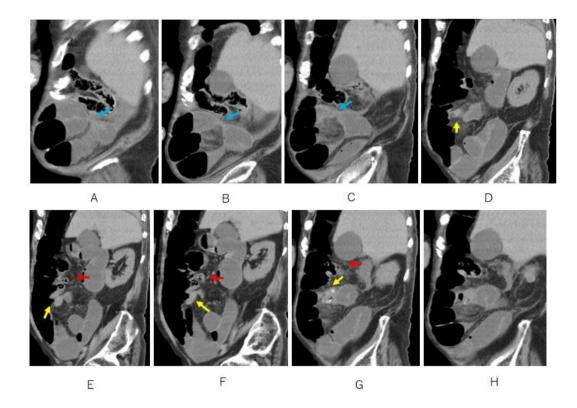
Occlusive site (A-C, blue arrow) adjacent with swollen appendix (D-G yellow arrow), ileum end (E-G red arrow) and mesenteric edema (H) are depicted on sagittal CT.
